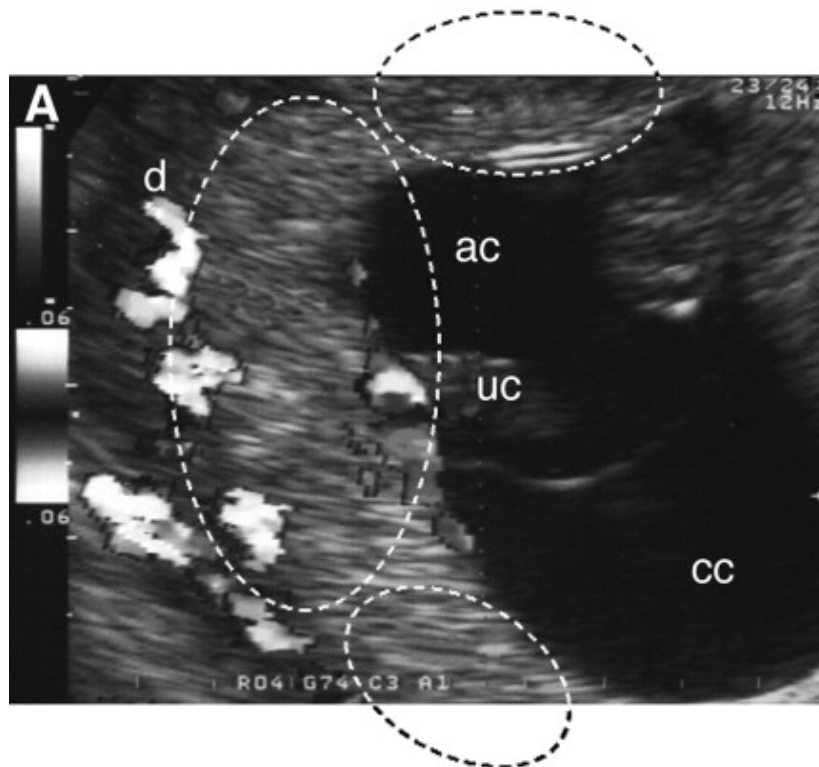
Mapping of the placental circulation at 8 weeks of gestation with colour Doppler showing the fetal circulation in the umbilical cord (uc) and the maternal circulation within the decidua (d). The dashed lines indicate the boundaries of the regions considered central and peripheral in this example (cc - chorionic cavity; ac - amniotic cavity). Reproduced with permission from Jauniaux et al.³⁵
